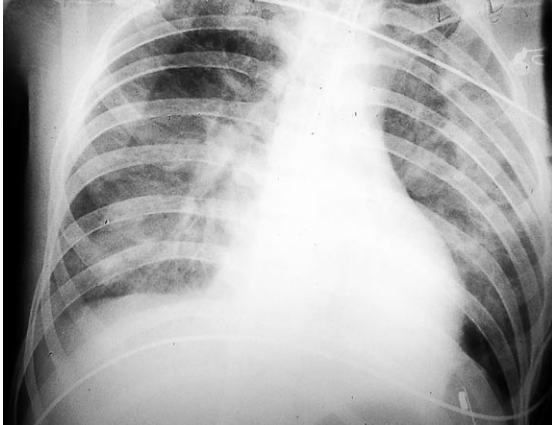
Chest radiograph shows bilateral alveolar opacities suggestive of pulmonary oedema.
